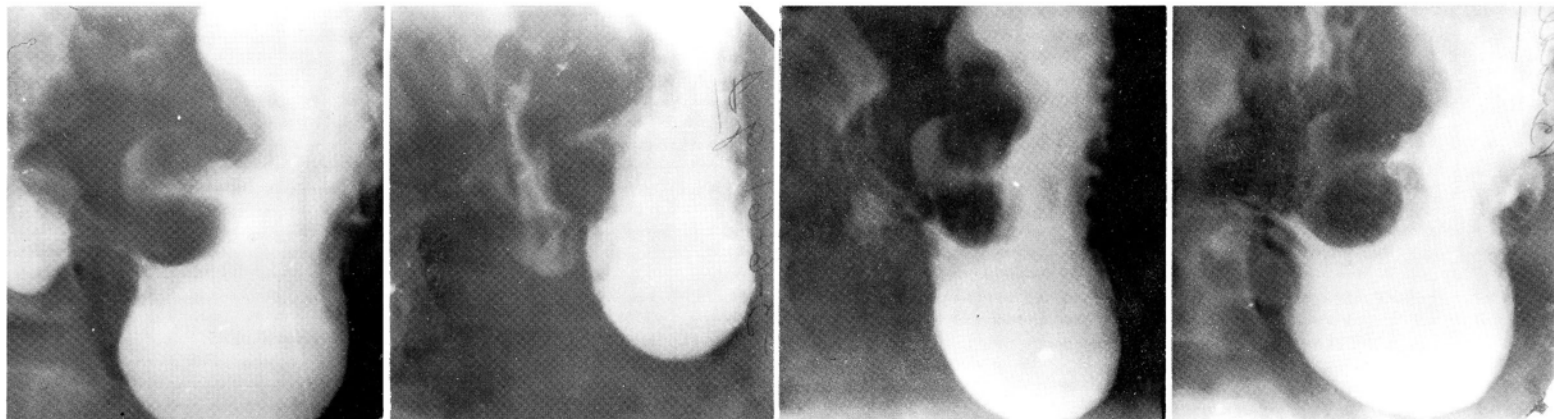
Spot roentgenograms showing two lobulated masses arising from the lesser curvature.
